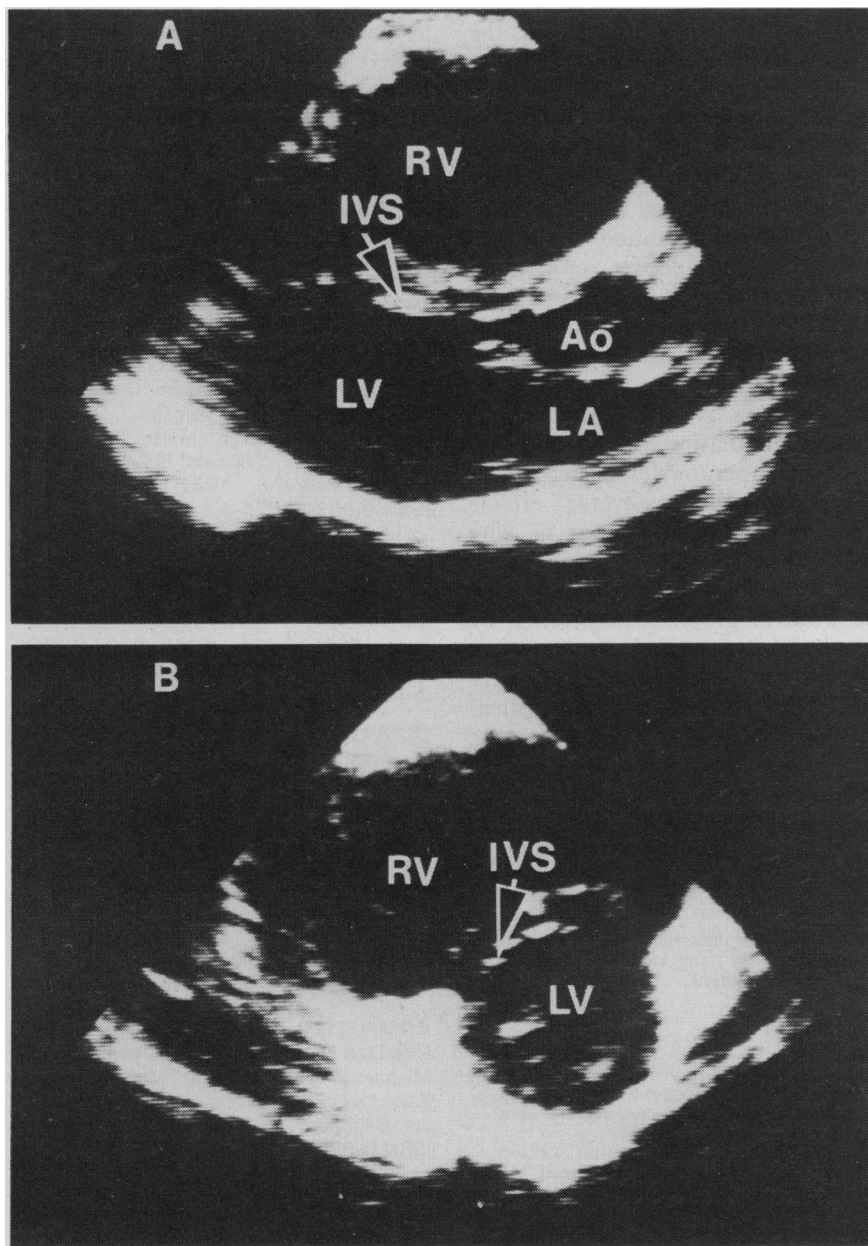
Single-frame, end-diastolic, two-dimensional echocardiograms (A, long-axis view; B, short-axis view) revealed enlarged and hypokinetic right ventricle (RV). LV = left ventricle; IVS = interventricular septum; LA = left atrium; Ao = aorta.
